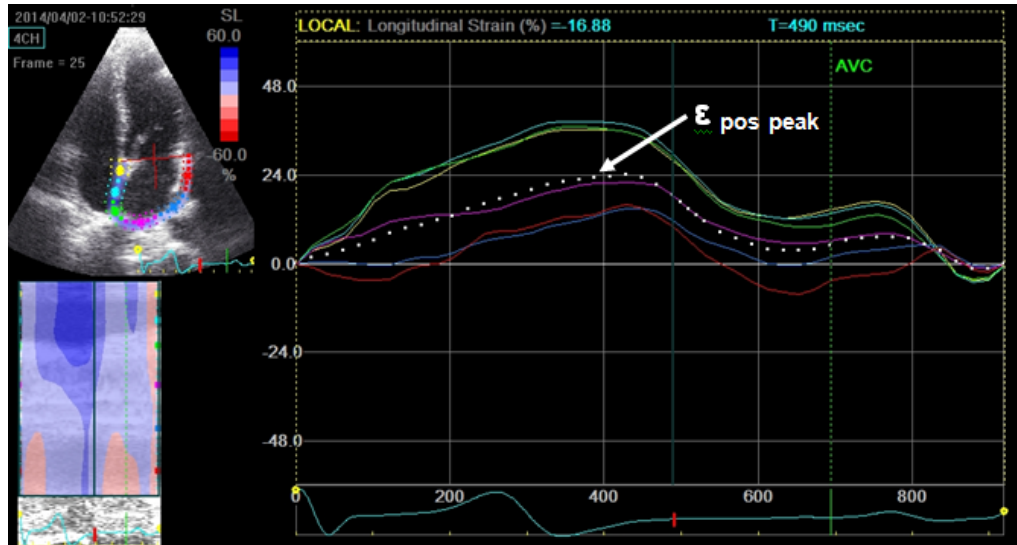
2D speckle tracking derived LA peak, positive longitudinal strain ( $\epsilon_{\text{pos peak}}$ ) measurement from apical 4 chamber view ( the reference point is the beginning of the QRS complex).
